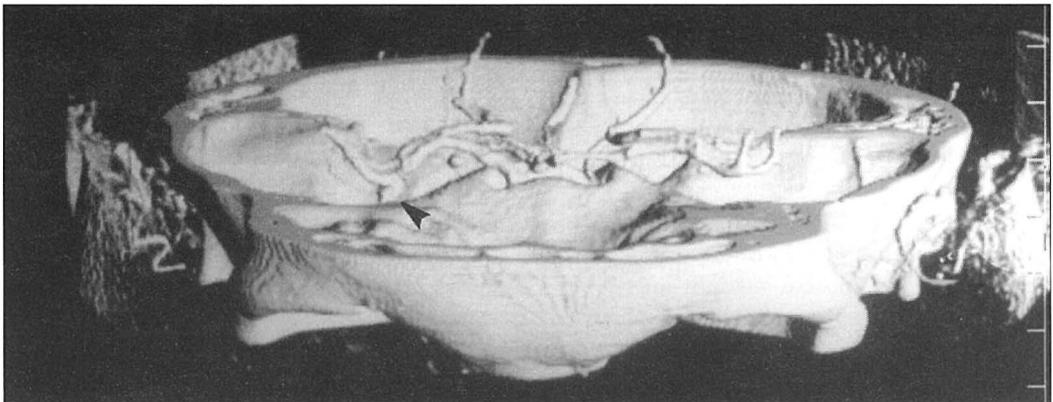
Patient with subarachnoid haemorrhage from a ruptured aneurysm of the middle cerebral artery. Intracranial CTA performed immediately after conventional CT clearly demonstrates the small aneurysm of the middle cerebral artery (arrow).
